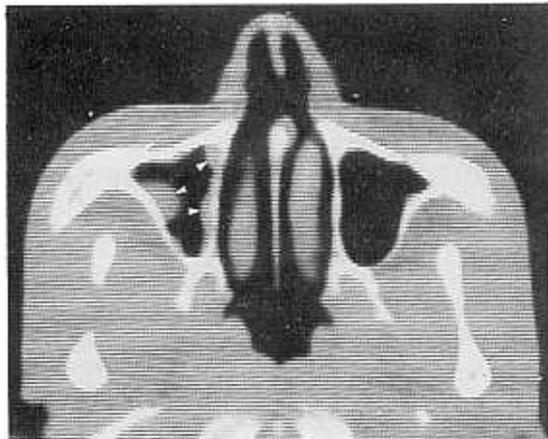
Axial CT section at the level of the maxillary antra and inferior conchas shows nodular mucosal thickening of right maxillary sinus (arrowheads).
